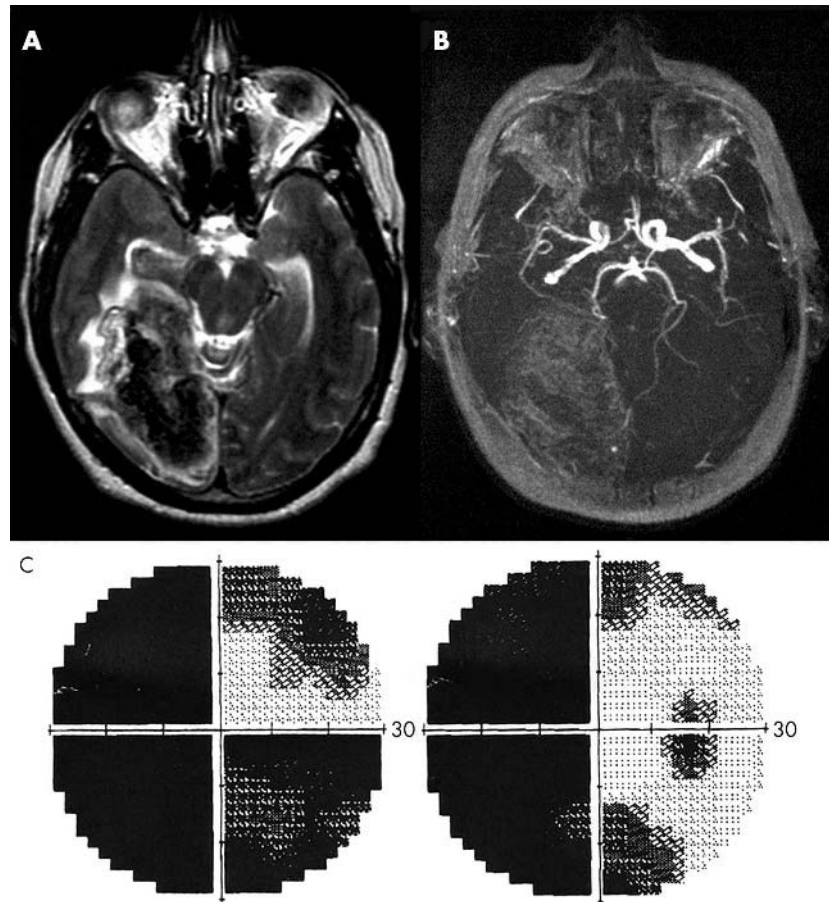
MRI (A), MRA (B), and Humphrey 30-2 visual fields (C) of our patient.
